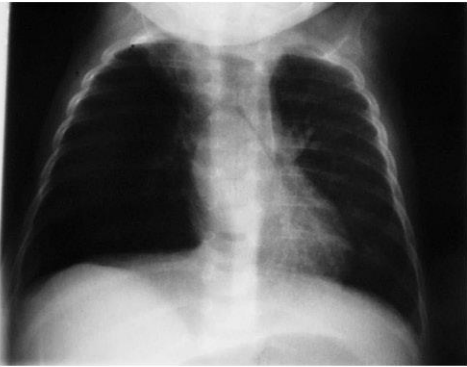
High-kilovolt chest radiograph demonstrating TB lymph node compression of both main bronchi.
